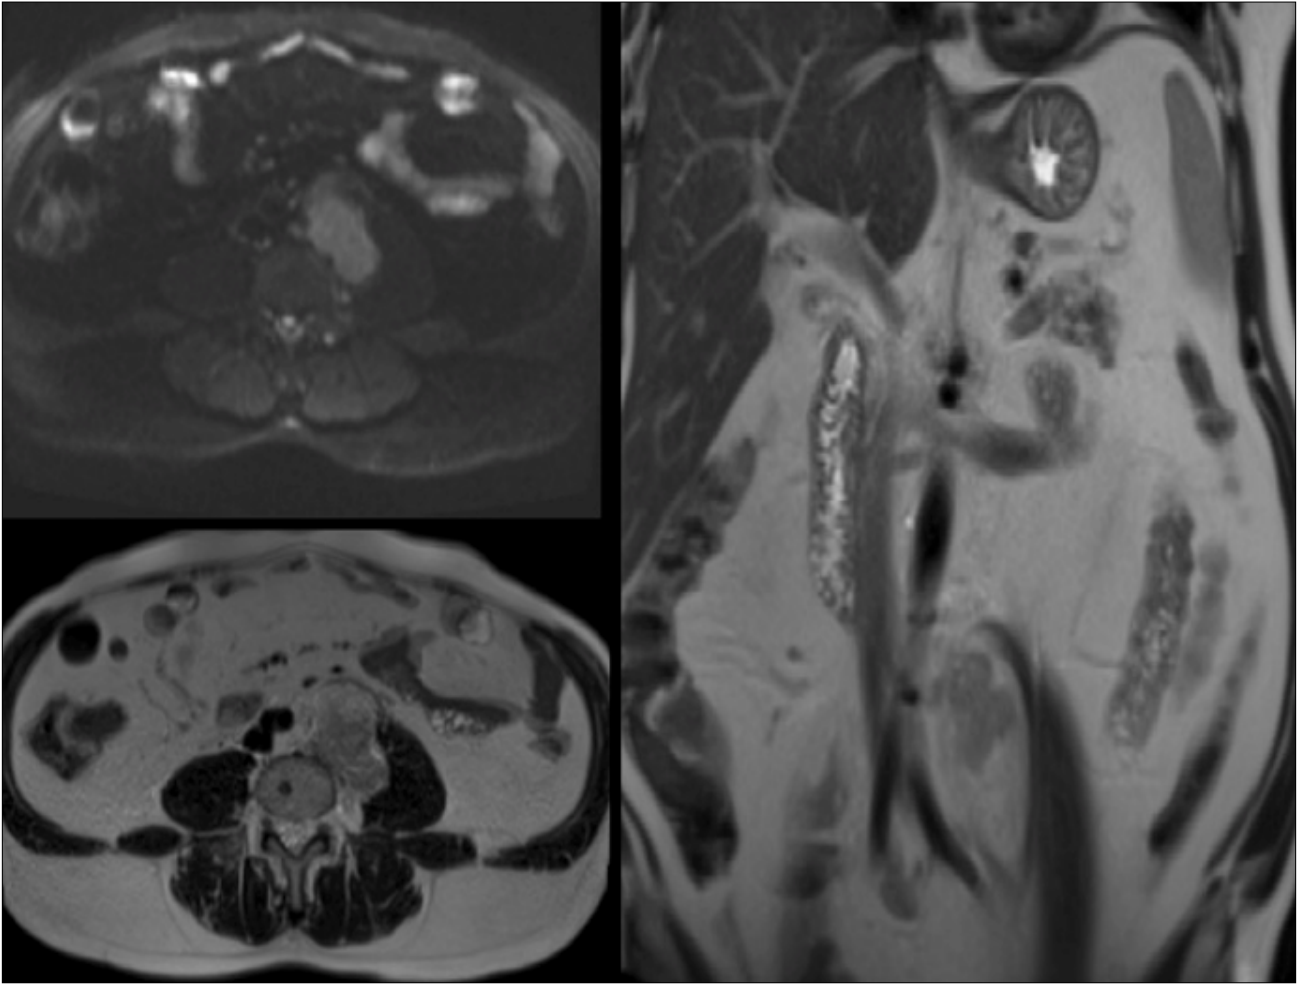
Magnetic resonance imaging (MRI) showing the lesion in question.
